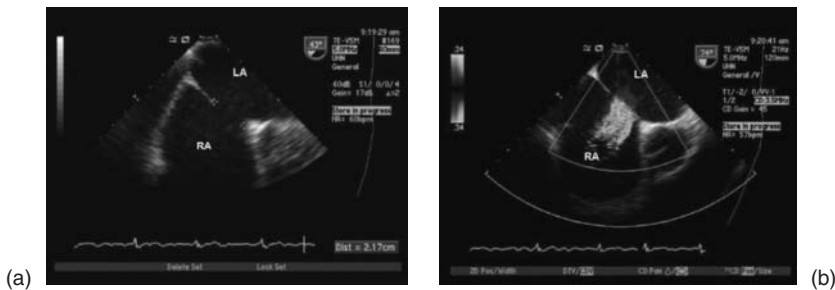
Transesophageal echocardiogram bicaval view of a 2.2 cm secundum ASD (1a) with left-to-right color flow across the defect (1b). RA, right atrium; LA, left atrium.
